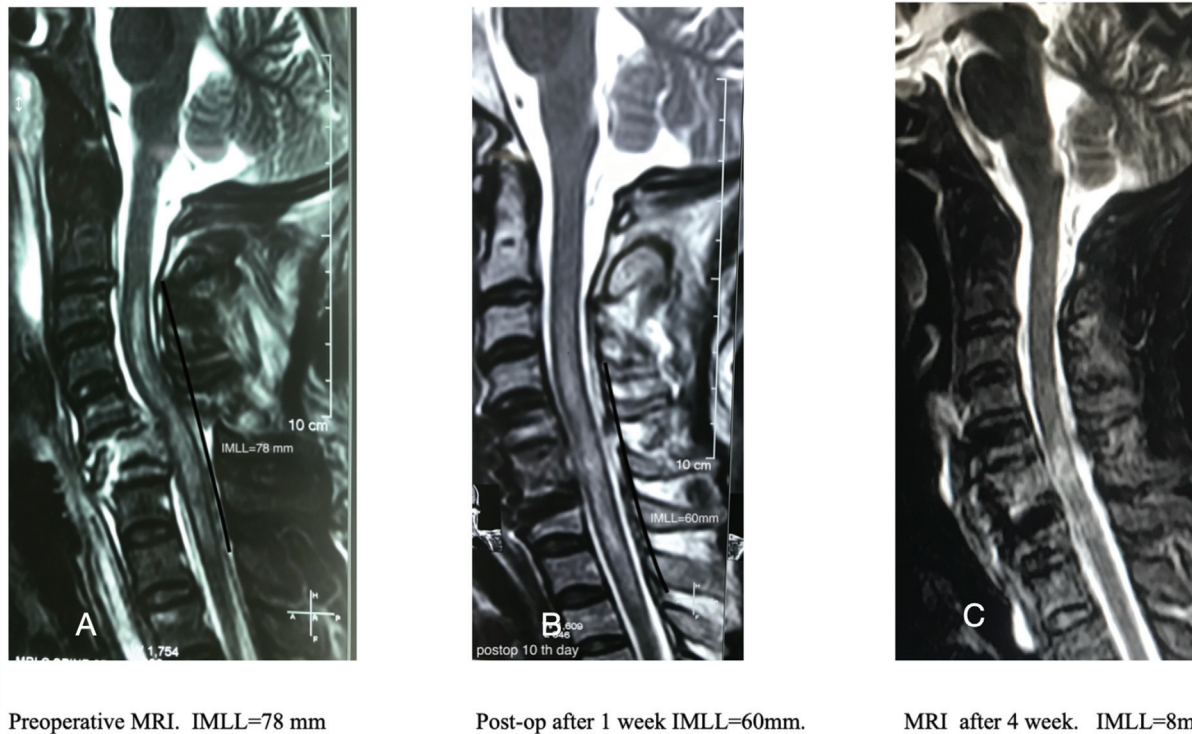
A 55-year-old woman sustained a fall and was brought to the emergency room 6 hours after trauma. At the time of admission, she was hypotensive and on a ventilator. Her American Spinal Injury Association scale (ASIA) Impairment Scale (AIS) grade was B. (A) Preoperative magnetic resonance imaging (MRI) of the cervical spine showed C6 vertebral body fracture with retropulsed fragment causing significant cervical cord compressive injury with bleeding at the epicenter and spinal cord edema extending from C3 to C8. It also shows a bright T2-weighted signal in the surrounding ligaments that is suggestive of disruption. The intramedullary lesion length (IMLL) was 78 mm. She underwent anterior cervical fusion within 24 hours resulting in proper realignment of the spinal column. (B) Postoperative MRI taken after 1 week of surgery indicated good decompression with significant improvement of intramedullary edema (IMLL = 60 mm). (C) MRI after 4 weeks showed a further decrease in IMLL to 8 mm. Six months later, her AIS grade was D.
